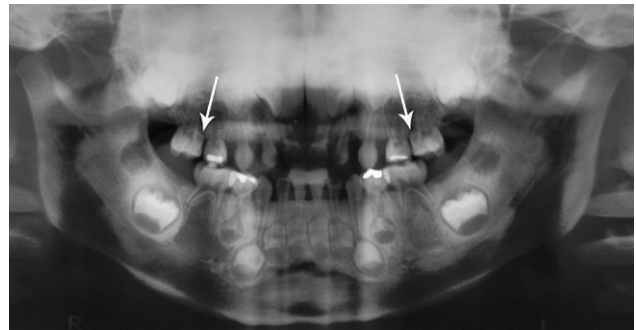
A panoramic radiograph of the patient's orofacial tissues. Thick bones were present in the midfacial area. The radiographic appearance of all primary teeth as well as the development of the permanent dentition appeared to be normal. The arrows indicate the "enamel pearl"—like excess mineralization of the primary maxillary second molars.
